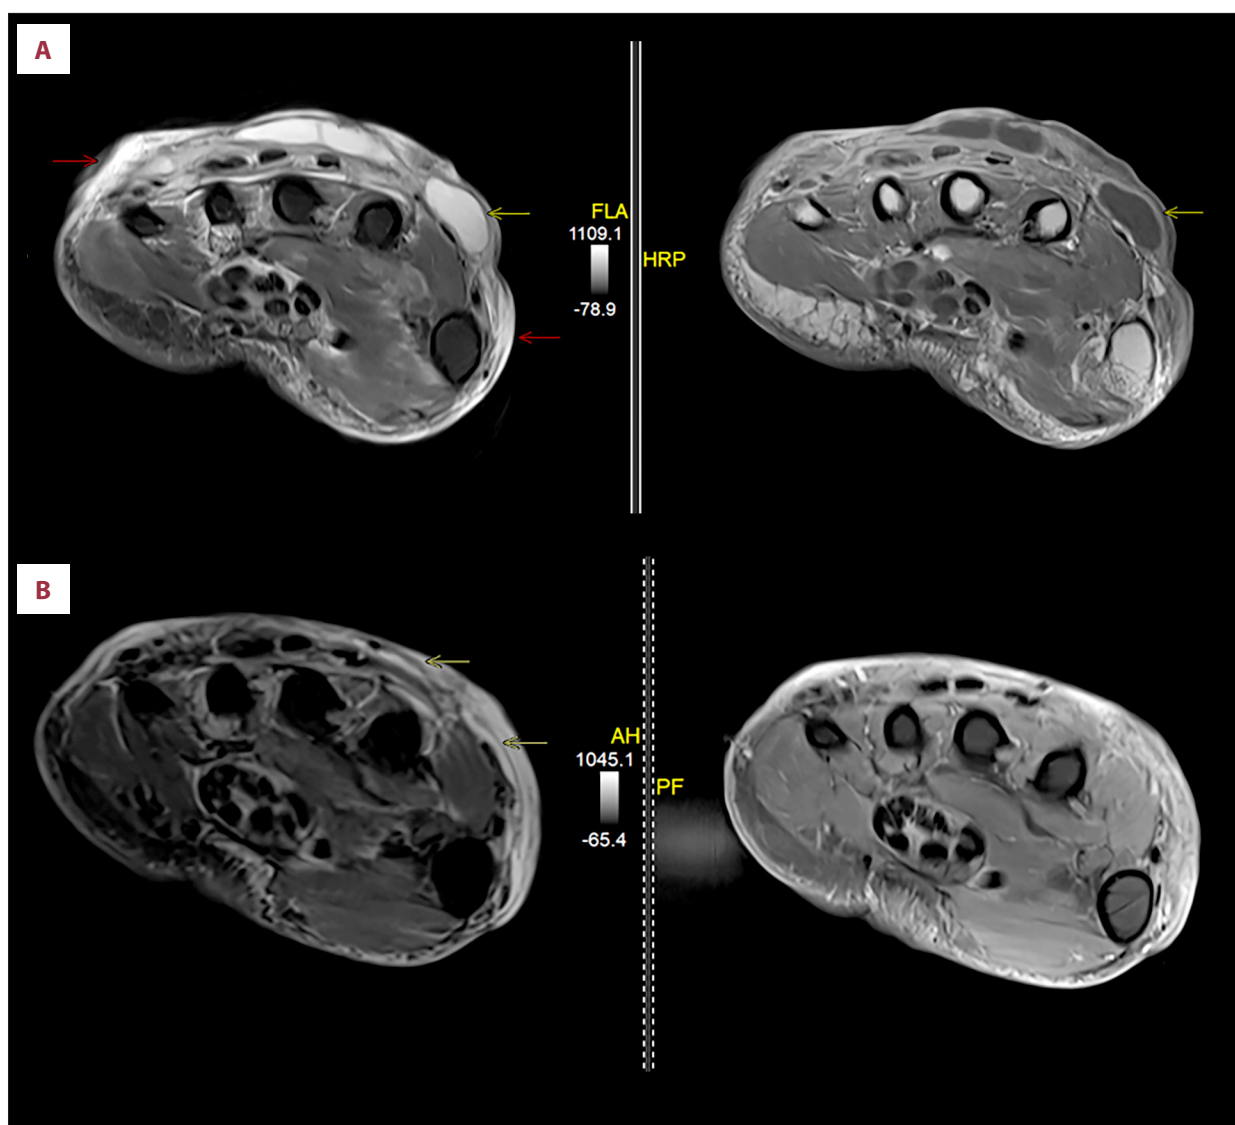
(A) Axial fat-suppressed T2-w and axial T1-w contrast-enhanced magnetic resonance images of the right hand at the level of the proximal metacarpals demonstrate extensive ill-defined subcutaneous edema (red arrows) and several rim-enhancing fluid collections (yellow arrows) involving the dorsal hand, suggesting cellulitis with abscesses. (B) Axial fat-suppressed T2-w and axial T1-w contrast-enhanced magnetic resonance images at the same level as in (A), which were obtained 8 weeks later, demonstrate near complete resolution of fluid collections (yellow arrows) with persistent but decreased subcutaneous edema of the dorsal hand.
